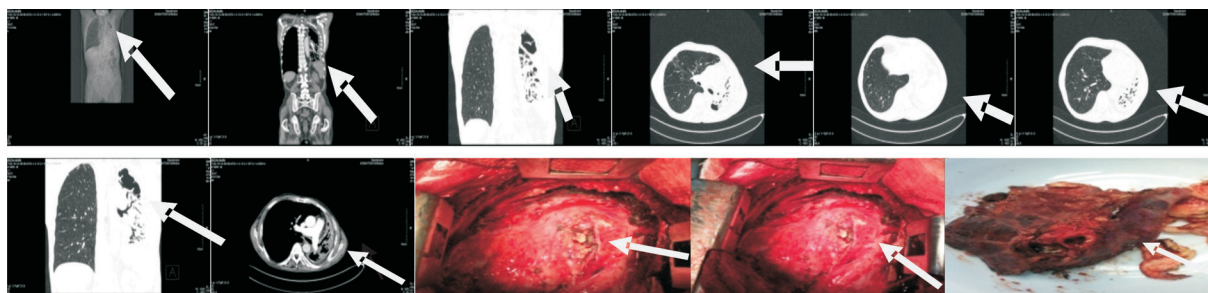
CT Bronchoectasi Saciforme Cistine, Pulmon sinister et finrothorax sinister.
